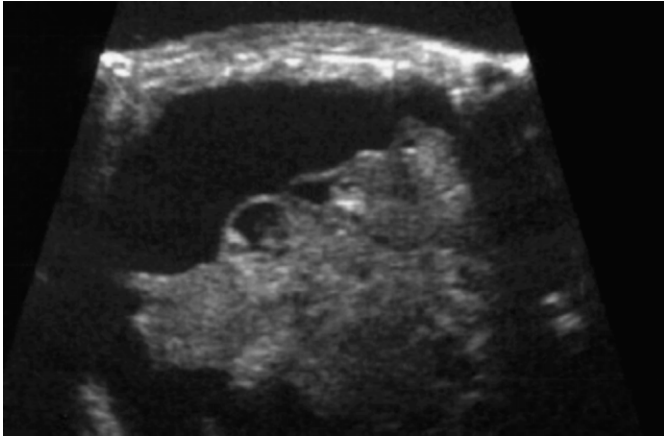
Sonography: large nodular neoformation of inhomogeneous echic structure for the presence of solid hypoechoic areas and cavity with fluid contents and thin inner septa.
